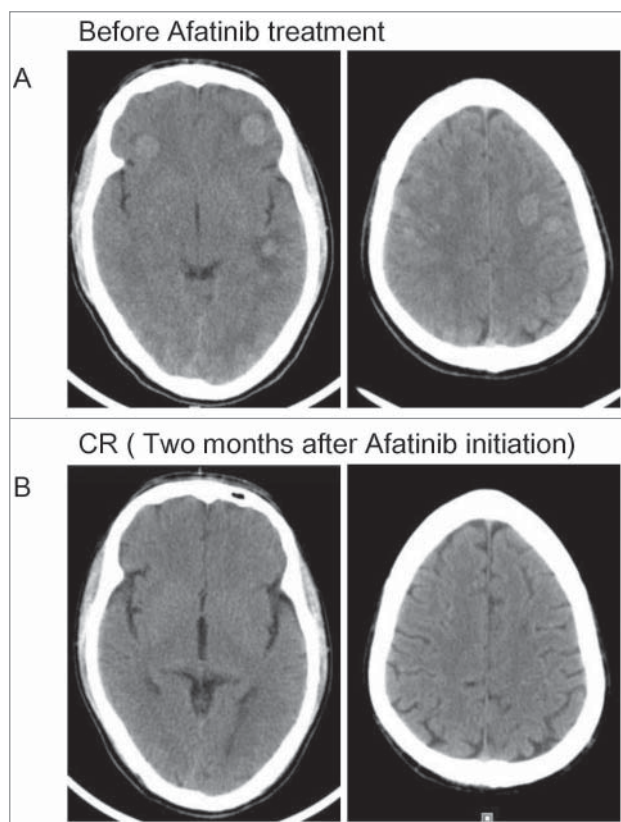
Head computed tomography scan revealed the tumor response to afatinib. (A) The progressive disease status of intracranial lesions before afatinib treatment. (B) Complete response of intracranial lesions after afatinib treatment.
